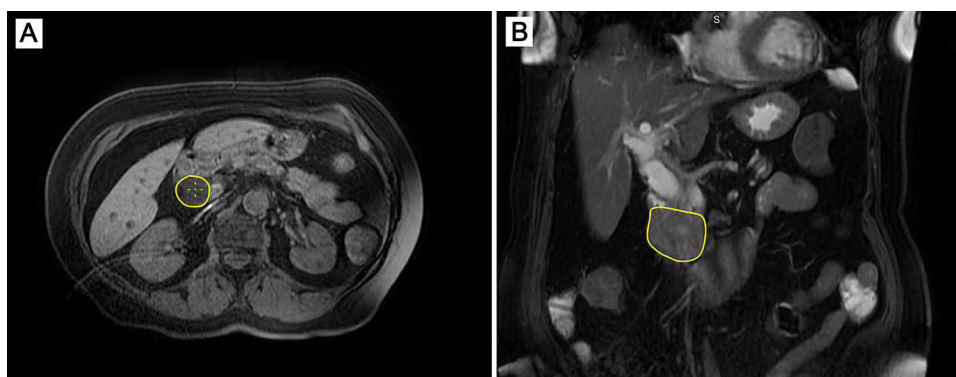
Preoperative imaging findings (CT, July 2024). Abdominal CT revealed a mass in the head of the pancreas measuring $4.7 \times 3.3 \times 3.8$ cm, with signs of local invasion and compression of the surrounding structures (shown as the yellow contour). (A) - axial CT plane, (B) - frontal CT plane.
